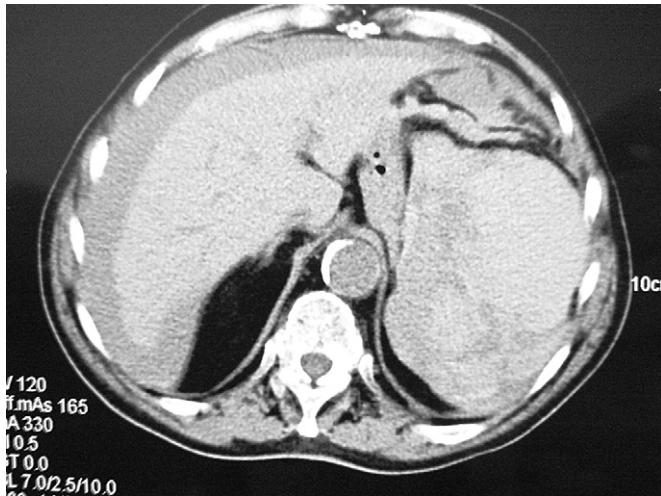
CT scan showing hemoperitoneum with spleen enlarged and its morphology disrupted by intraparenchymal hemorrhage, 48 h after colonoscopy.
